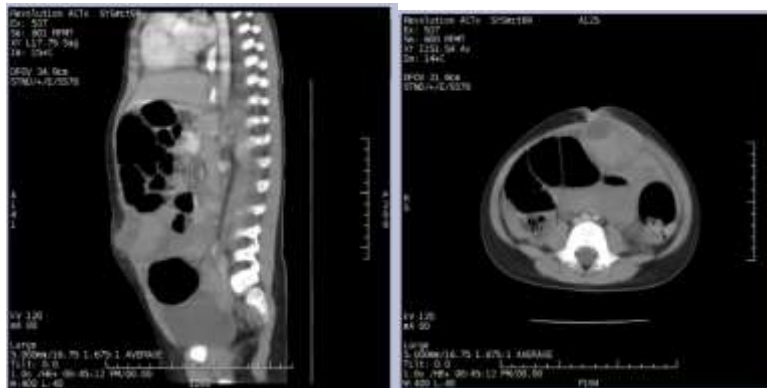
Coronal and axial contrast-enhanced abdominal CT scan shows an irregular cystic mass of 5.5x4.6x5 cm size in the abdominal cavity that adheres to the anterior wall of the abdomen and bowel structure with a fluid-solid level without enhancement, also partial ileus
